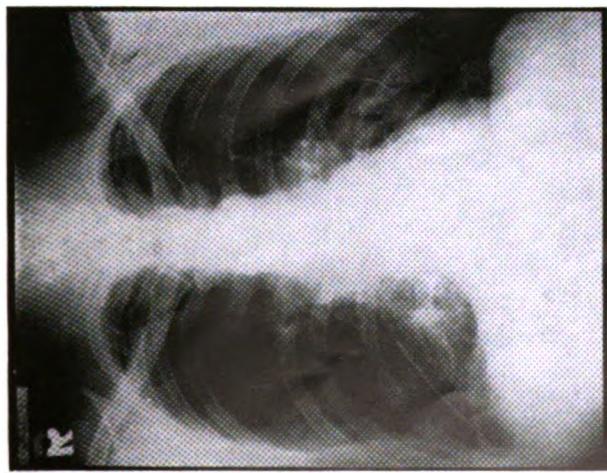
P.A. radiograph of the chest during convalescence after the lipothymoma had been excised.
